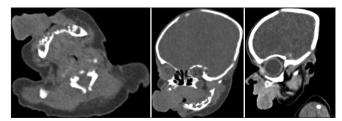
Pre-operative non-contrast computed tomography of the head
